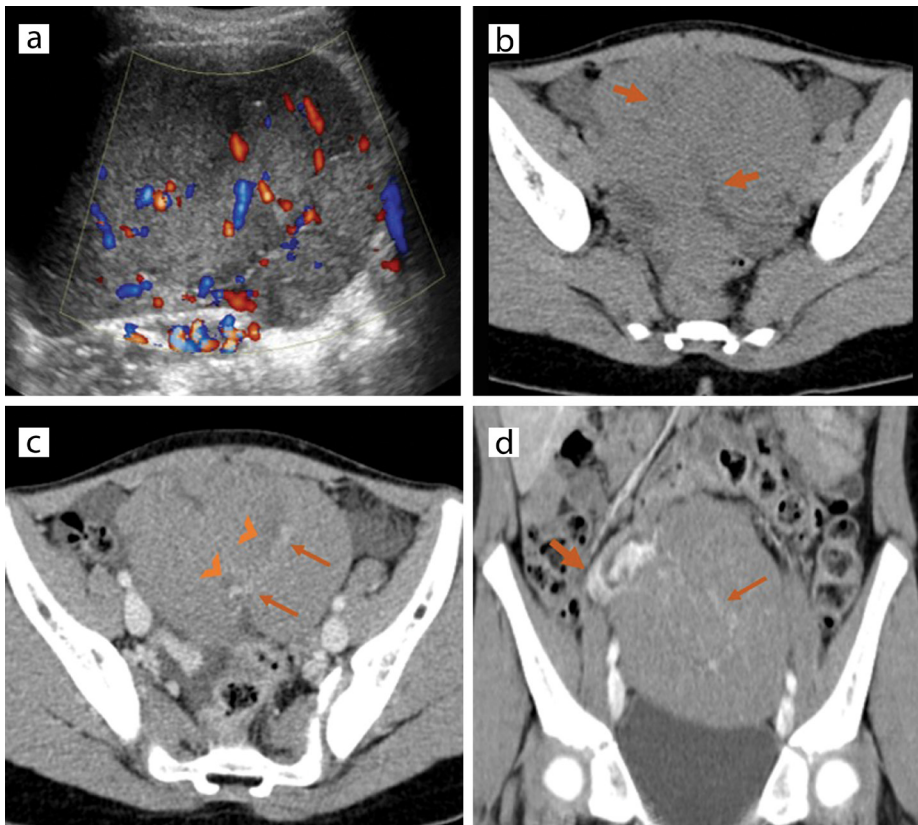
A 10-year-old female patient was diagnosed with right ovarian dysgerminoma. Transabdominal color Doppler US image (a) showing a solid mass with heterogeneous echogenicity and richly vascularized septa. Axial pre-contrast (b) and axial and coronal contrast-enhanced CT images (c, d) revealing a solid pelvic tumor with thick hypoattenuating septa (thick arrows, b) with enhancing vessels (thin arrows, c, d) and edematous non-enhancing components (arrowheads, c). Note the “ovarian vascular pedicle” sign, with enlarged right ovarian vein (thick arrow, d). CT, computed tomography.
